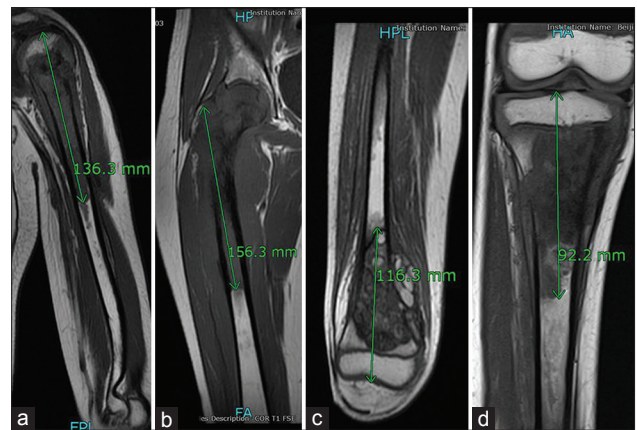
Representative images of magnetic resonance imaging measurements for patients with tumors located in the proximal humerus (a), proximal femur (b), distal femur (c), and proximal tibia (d).
